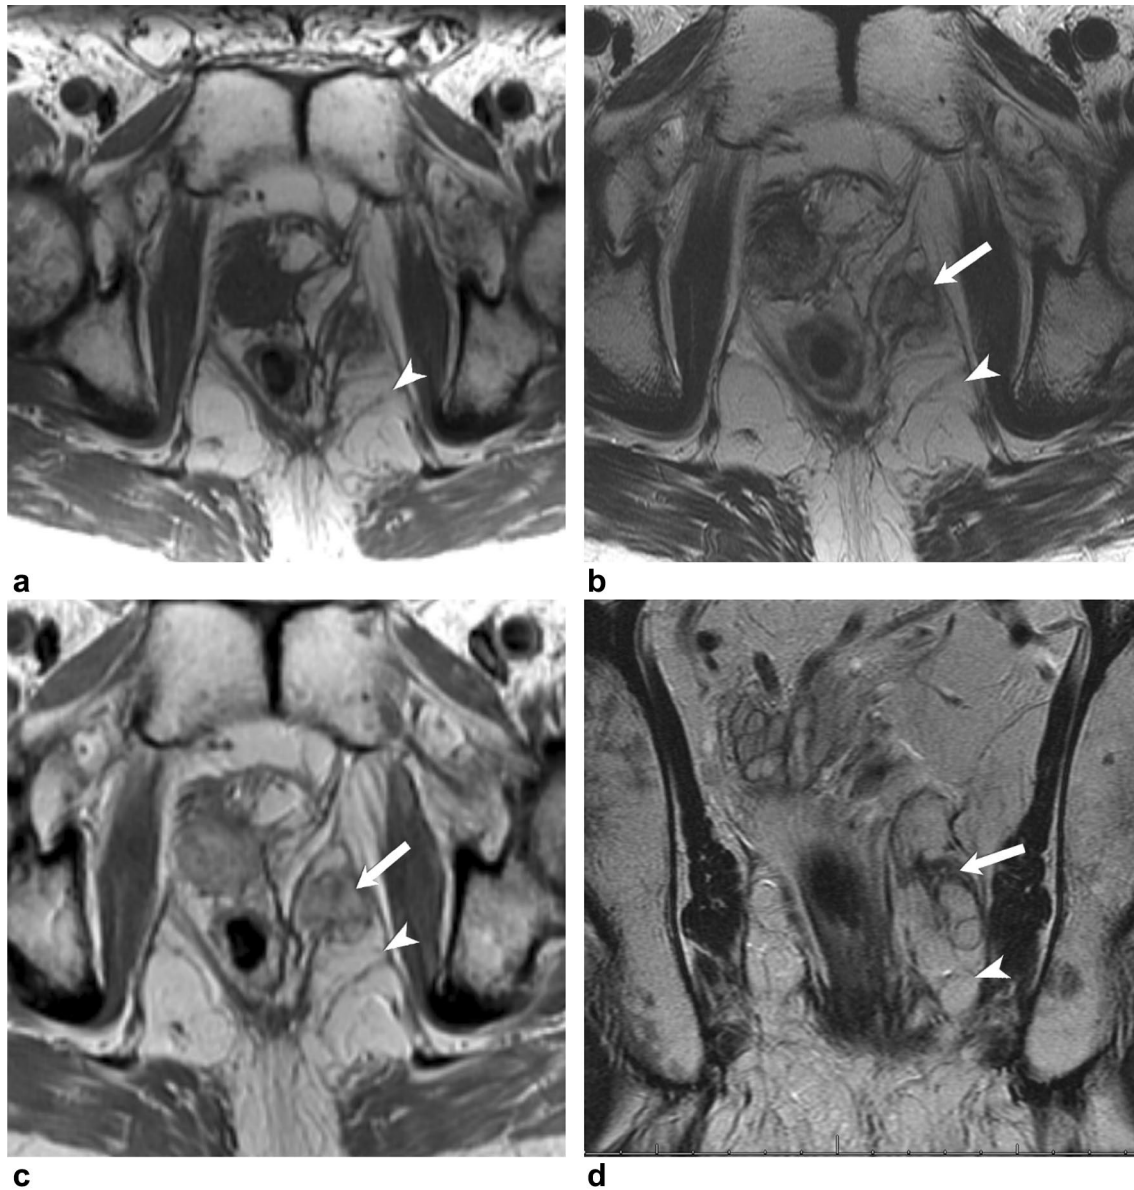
61-year-old male presents with growing mass in the left peri-rectal region, for which he underwent pelvic MRI for assessment. a Axial T1WI (a) showing a fatty mass (white arrowhead) in the left ischio-rectal fossa. b, c Axial T2WI (b), and post-contrast axial T1WI (c) show the fatty mass (white arrowheads) in the fossa. Low signal intensity soft tissue (white arrows) is noted, which shows contrast
